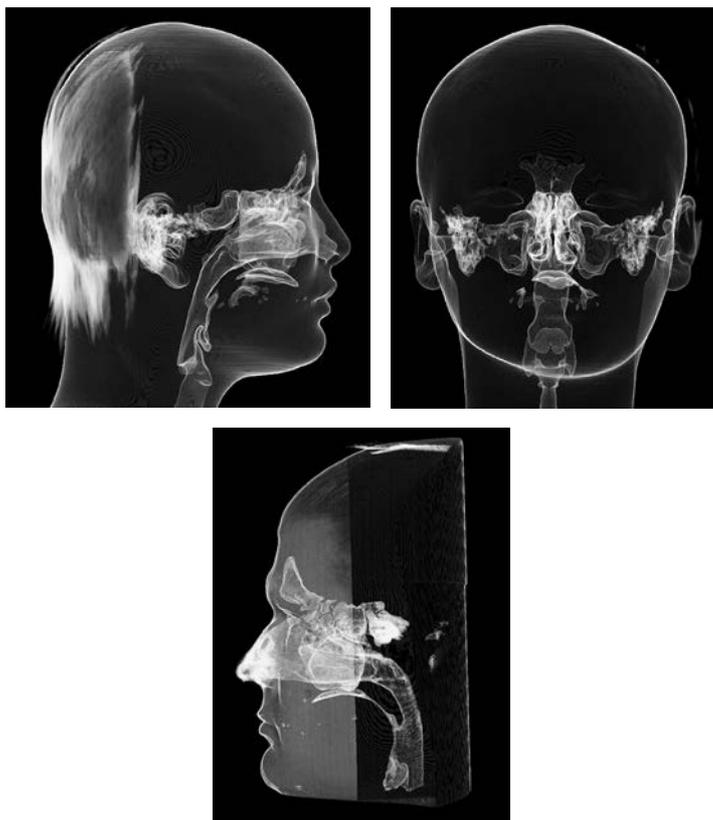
Analyzing the airway with only a lateral film would not be able to identify a possible airway lateral constriction abnormality. A) Lateral and B) Frontal view of the airway by using CBCT. The airway can be segmented and analyzed volumetrically in three dimensions. C) Close-up of the airway in a surface mode (Courtesy of Anatomage Inc. – San Jose, CA).
